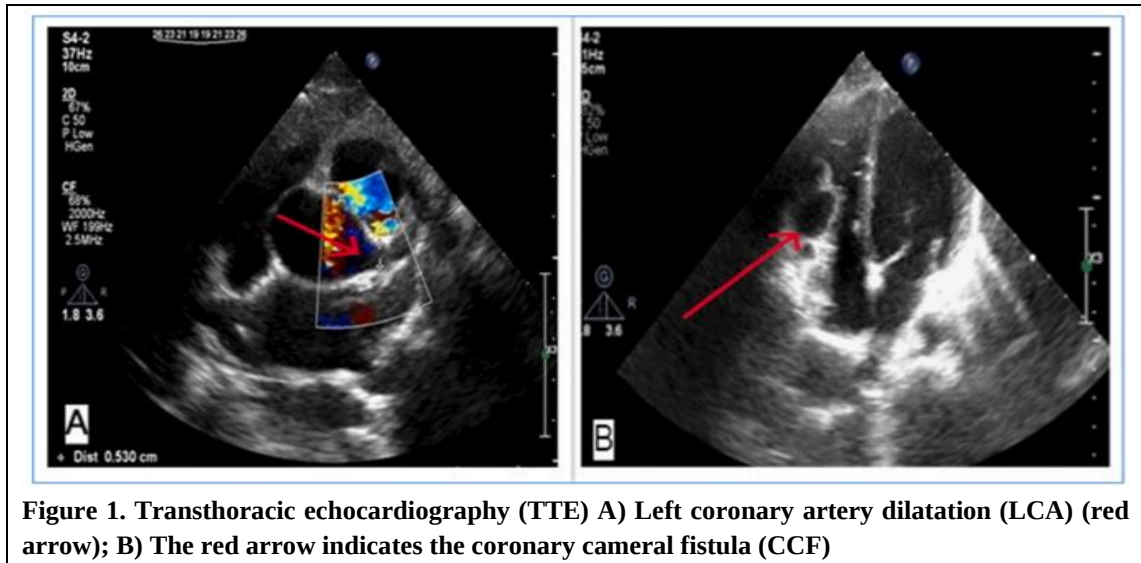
Transthoracic echocardiography (TTE) A) Left coronary artery dilatation (LCA) (red arrow); B) The red arrow indicates the coronary cameral fistula (CCF)
